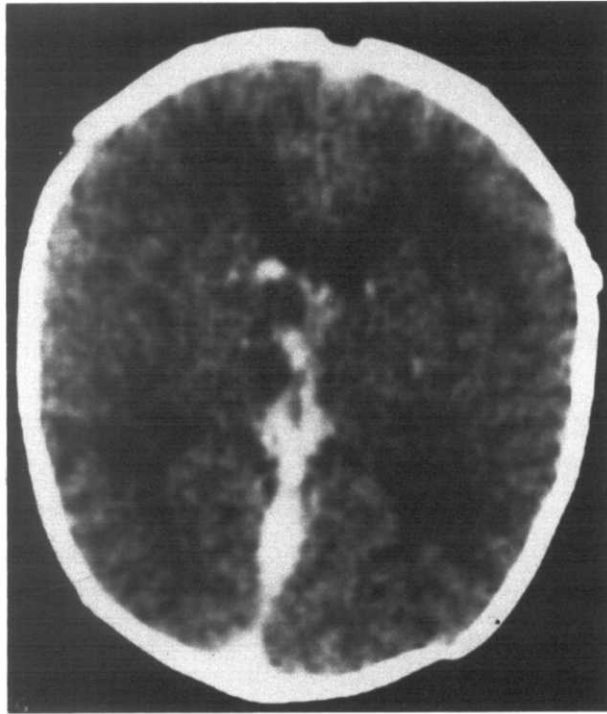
Cranial CT of Patient 2 revealing hemorrhage bilaterally over the region of the head of the caudate (more marked on the right) and hemorrhage along the right thalamus.
